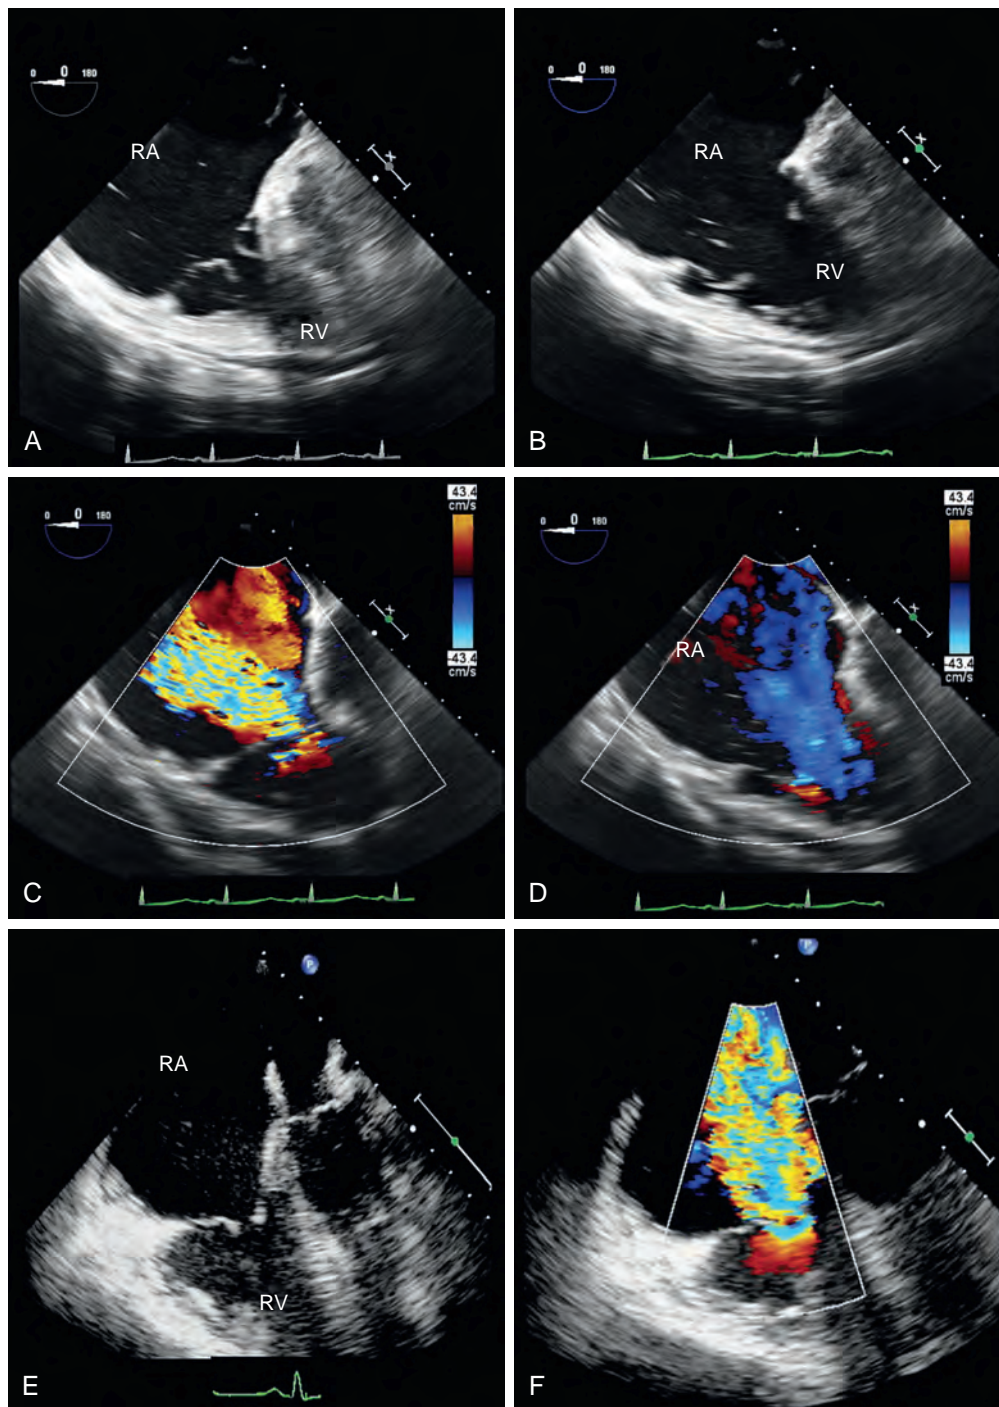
Restricted tricuspid valve (TV) leaflet. Contrasting Fig. 15.85, these images were obtained from two different cases of restricted tricuspid leaflet causing severe tricuspid regurgitation (TR). (A–D) Images from a patient with rheumatic disease (confirmed by pathologic examination) during (A and C) systole and (B and D) diastole with two-dimensional and color Doppler imaging. (C) Severe TR. (E) and (F) Carcinoid involvement (confirmed by pathologic analysis) of the TV. In both cases severe TR was present and both patients underwent valve replacement. RA, Right atrium; RV, right ventricle.
